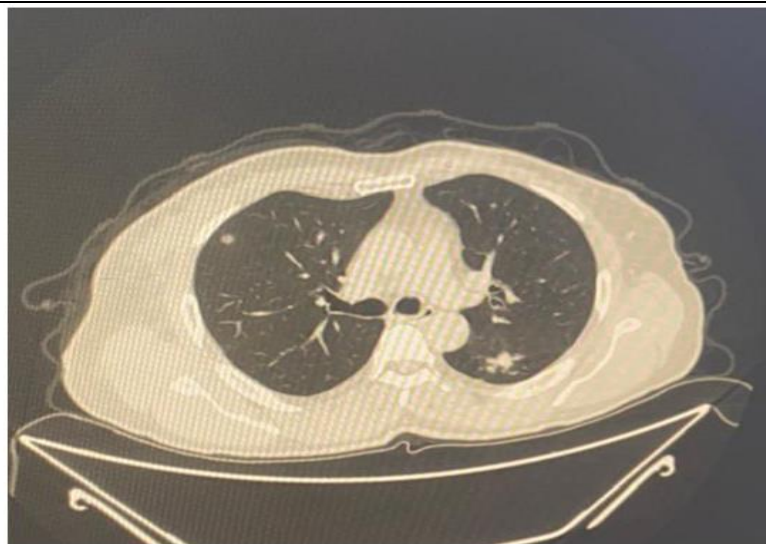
CT CAP showed multiple pulmonary metastasis.
